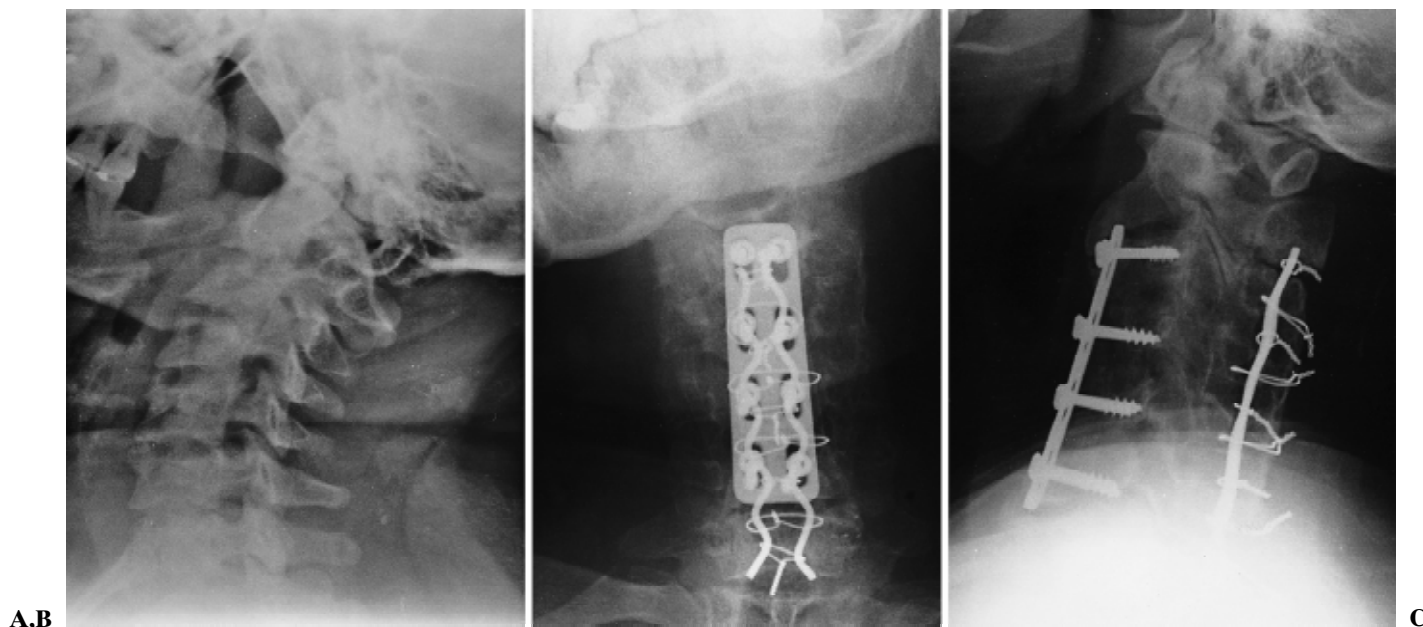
Roentgenograms in case 2. A Lateral radiograph showing spondylotic changes and instability between C3 and C6. B Anteroposterior and C lateral radiographs made 13 years after surgery, revealing complete bony union between
